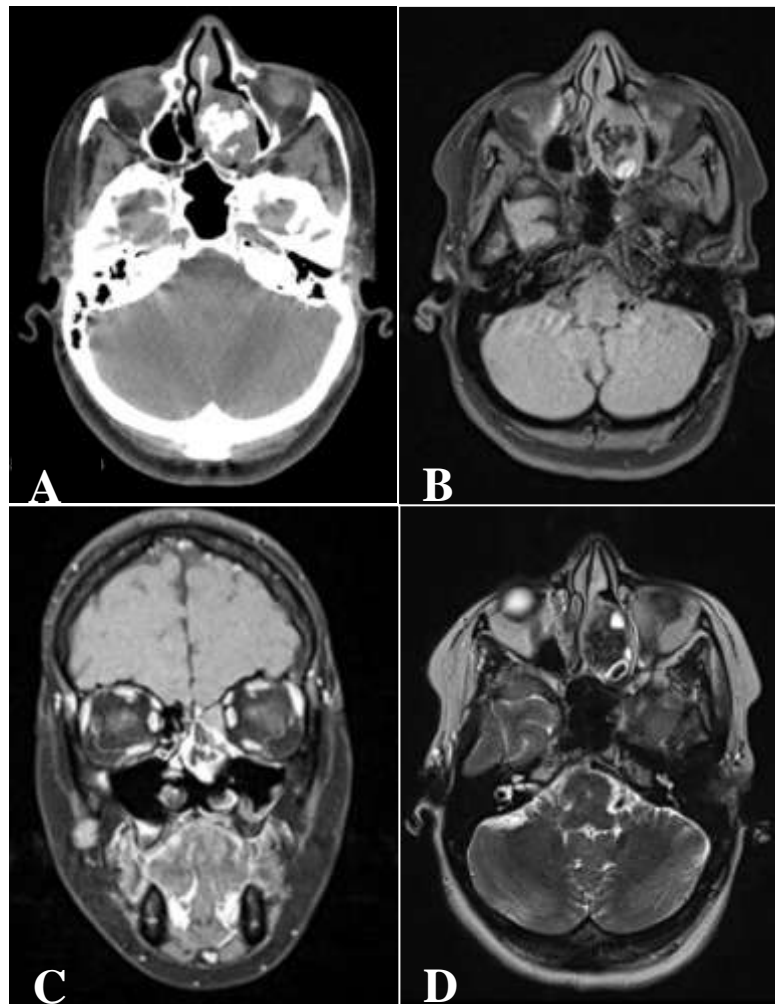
(A) Axial CT scan showing the well-defined, irregularly contoured tissue tumor within the left nasal cavity. (B,C) Axial and coronal MRI T1-weighted after gadolinium injection showing that the tumor occupies the left nasal cavity and exhibits a discrete heterogeneous iso-signal, with marked enhancement after gadolinium injection. (D) Axial MRI T2-weighted showing an heterogeneous intermediate low-signal intensity tumor.
